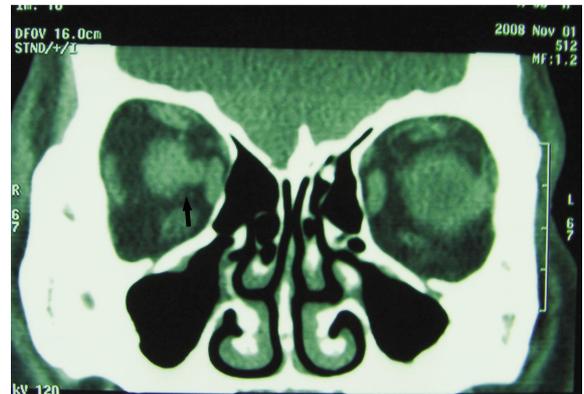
No gap between the optic nerve and CH in different coronal CT images (black arrow) in case 1
